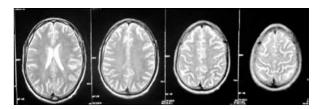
MRI scan report showing the ischemic changes of small vessels, non-hemorrhagic infarcts.
